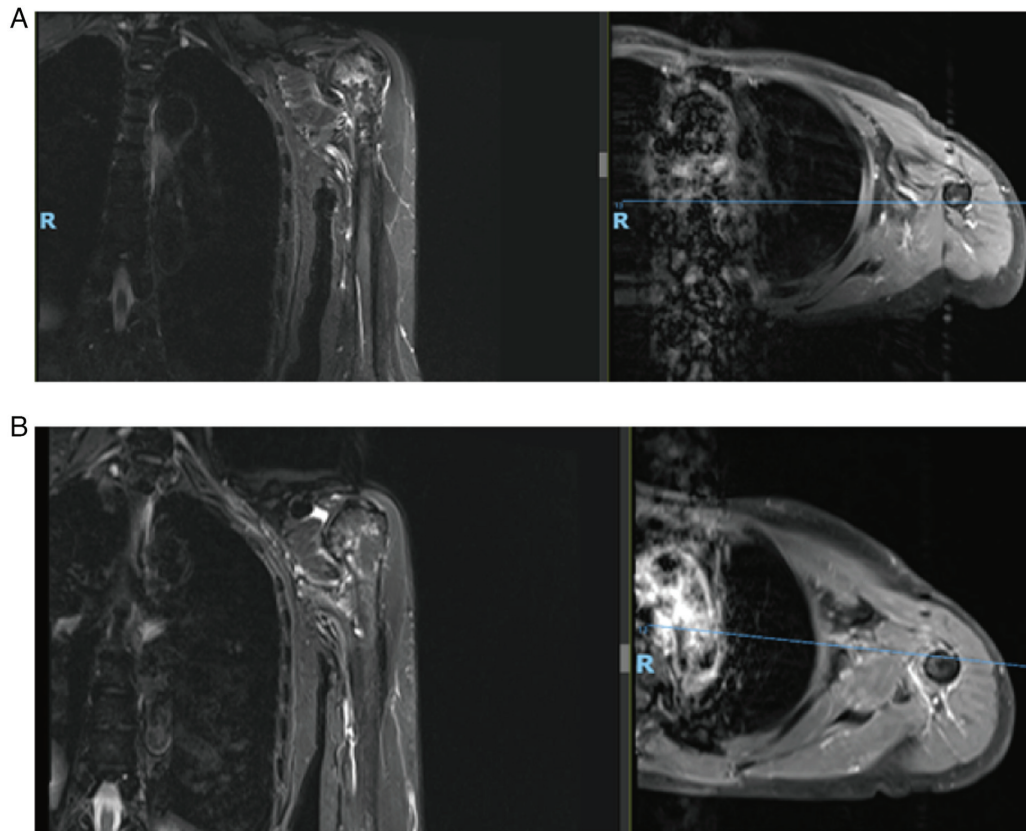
Reexamination of MRI after patient treatment. (A) Reexamination using MRI after radiation confirmed the reduction in the size of the tumor to 2.8x1.1x1.1 cm. (B) Reexamination using MRI after 1 cycle of tyrosine kinase inhibitor-targeted therapy indicated that the tumor had completely disappeared. MRI, magnetic resonance imaging.
